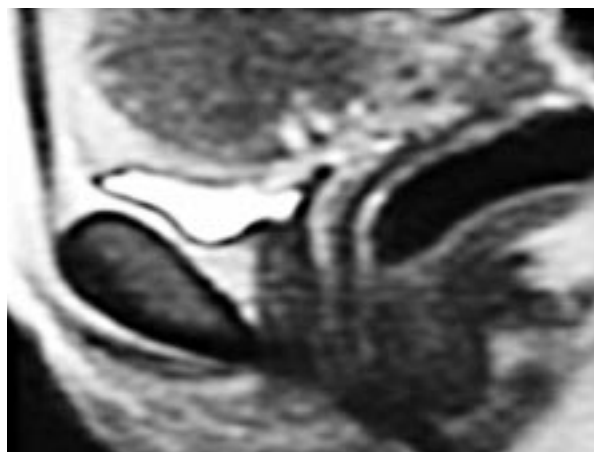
a : Pelvic floor MRI: Mid sagittal image - relaxed
